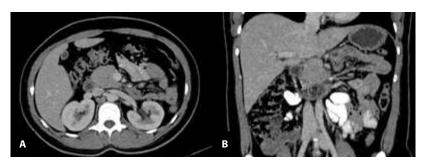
Helical CT of the abdomen, with oral and intravenous contrast. Axial section (A) and coronal section (B) in venous portal phase. Post-surgical changes consistent with a corpo-caudal splenopancreatectomy are evidenced. The pancreatic head is preserved. There is no evidence of tumor remnants or recurrences, nor intra-abdominal metastatic lesions or adenopathies
